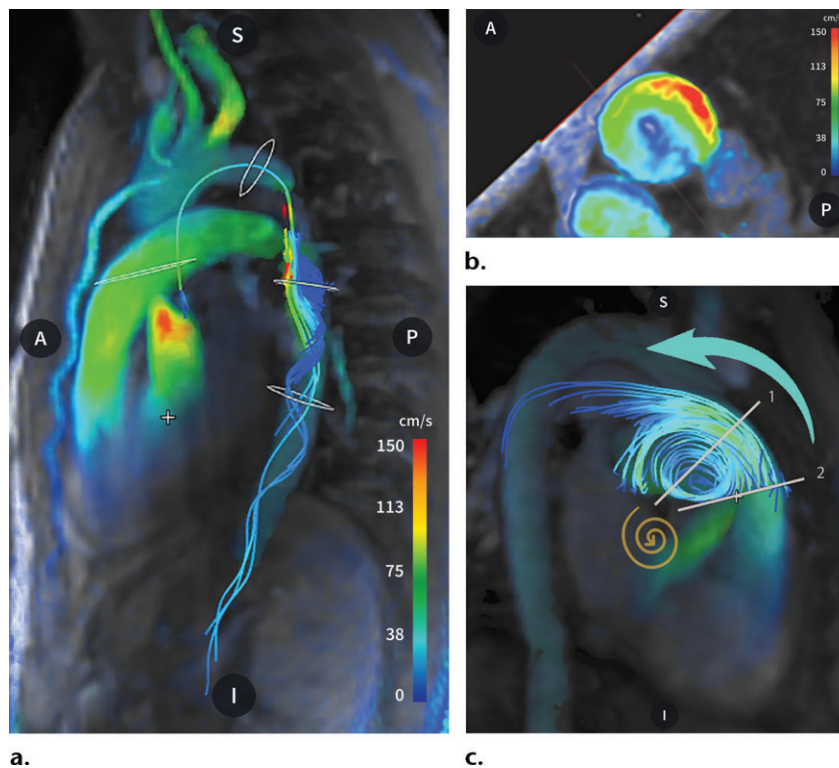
Four-dimensional flow MRI provides a comprehensive view of different blood flow patterns. (a) Image with streamlines in a young adult with severe aortic coarctation shows aortic poststenotic helical flow in the descending aorta during systole. (b) Cross-sectional view of the ascending aorta in a patient with a bicuspid aortic valve shows eccentric high-velocity jet flow (red) adjacent to the lateral aortic wall. (c) Image with streamlines shows systolic pulmonary artery forward flow (blue arrow) in a young adult with pulmonary regurgitation 18 years after tetralogy of Fallot repair. The streamlines also demonstrate vortical flow (gold arrow) in the aneurysmal pulmonary artery. Streamline visualization improves positioning accuracy for blood flow measurement perpendicular to the axis of the vessel (levels 1 and 2) and allows avoidance of areas of vortical flow (level 2), thus improving the accuracy of assessment of pulmonary regurgitation severity. Pulmonary regurgitation was estimated to be severe (level 1) or moderate (level 2).
